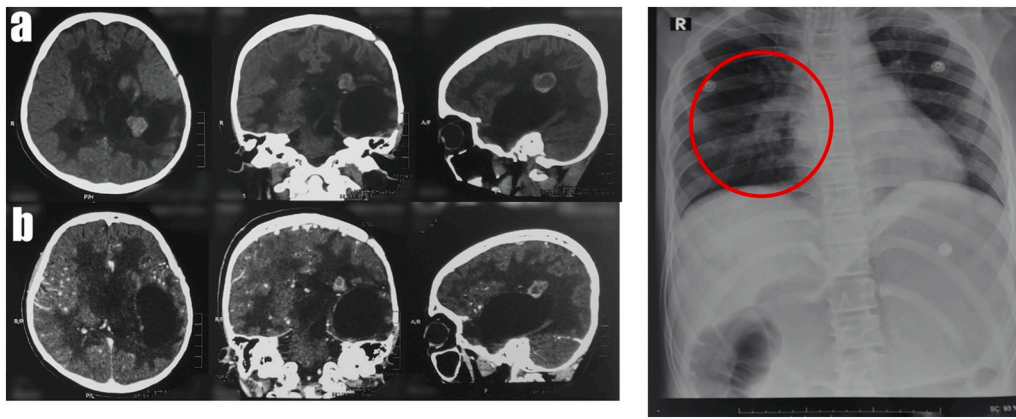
Imaging evaluation of CT scan; non contrast (a), with contrast (b); and chest x-ray (c).
